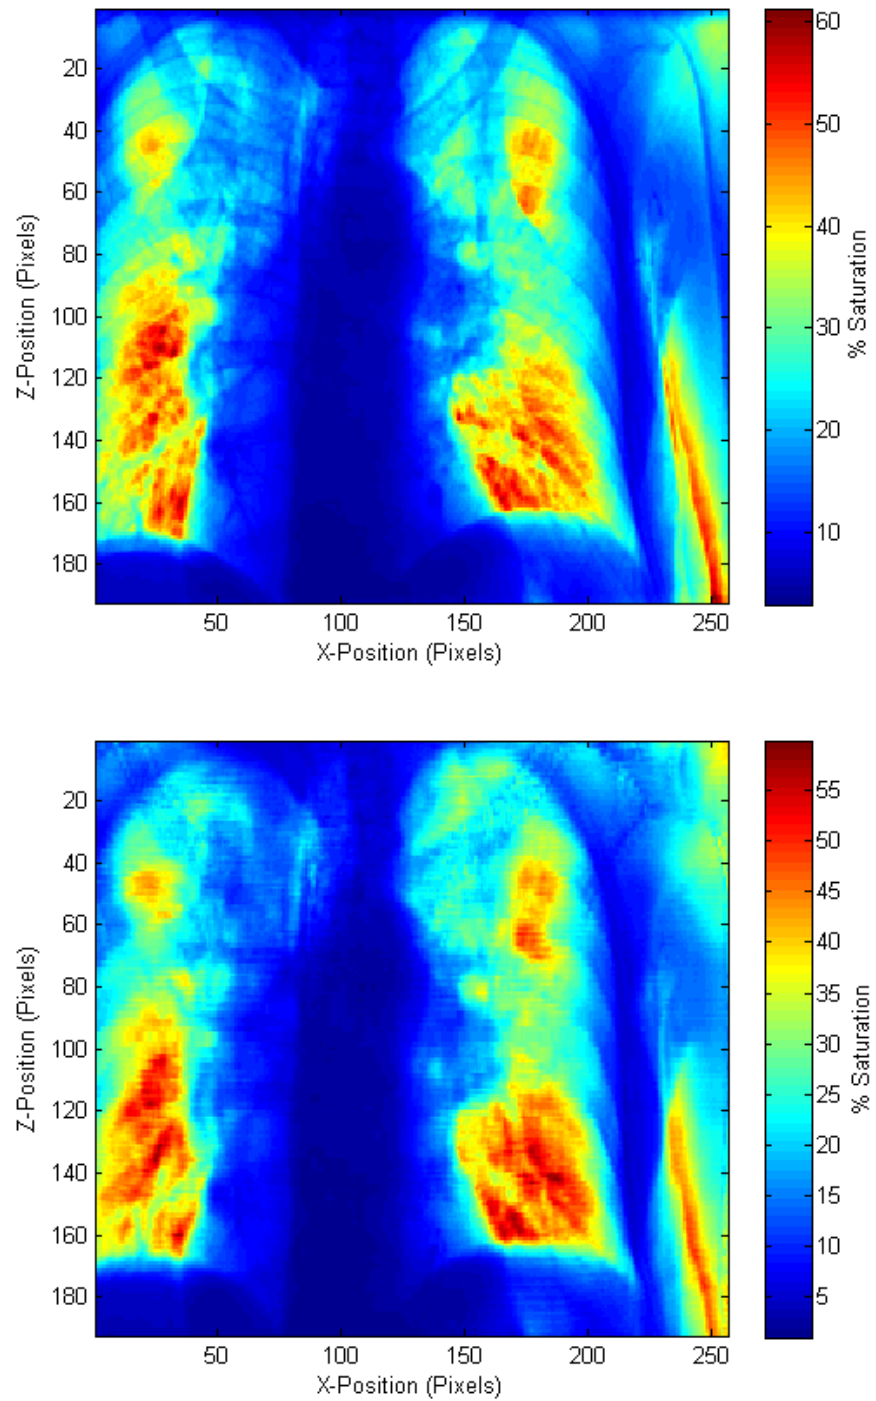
Chest radiograph of a patient acquired at 120 kVp and 8 mAs. The top image was taken of the patient during a fraction of IGRT and the bottom image was calculated by the DRR software.
